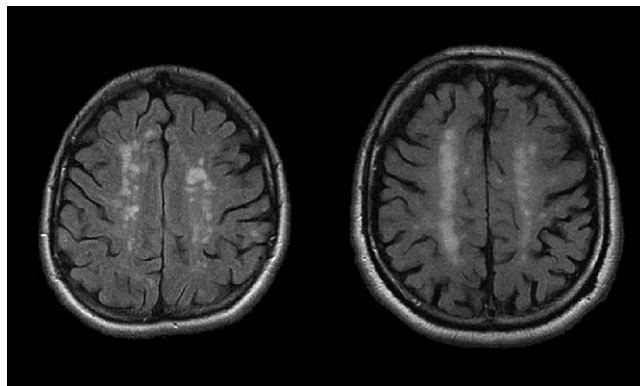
Axial FLAIR images from a 43-year-old male with MS (left) and from a 51-year-old male with CM (right).
